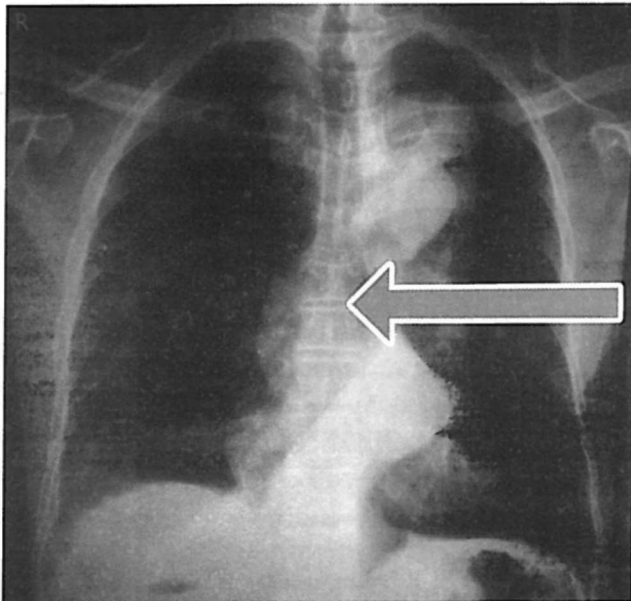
Chest X-ray (PA) reveals a grossly unfolded aorta with lobulated outline and double density shadow overlying the heart, not silhouetting the left cardiac border.(see arrow)
